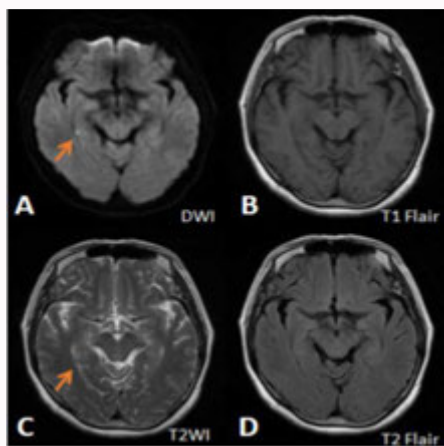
MRI imaging of patient at three days after onset (A-D). The red arrow point to a recent ischemic lesion in the right hippocampus area.
